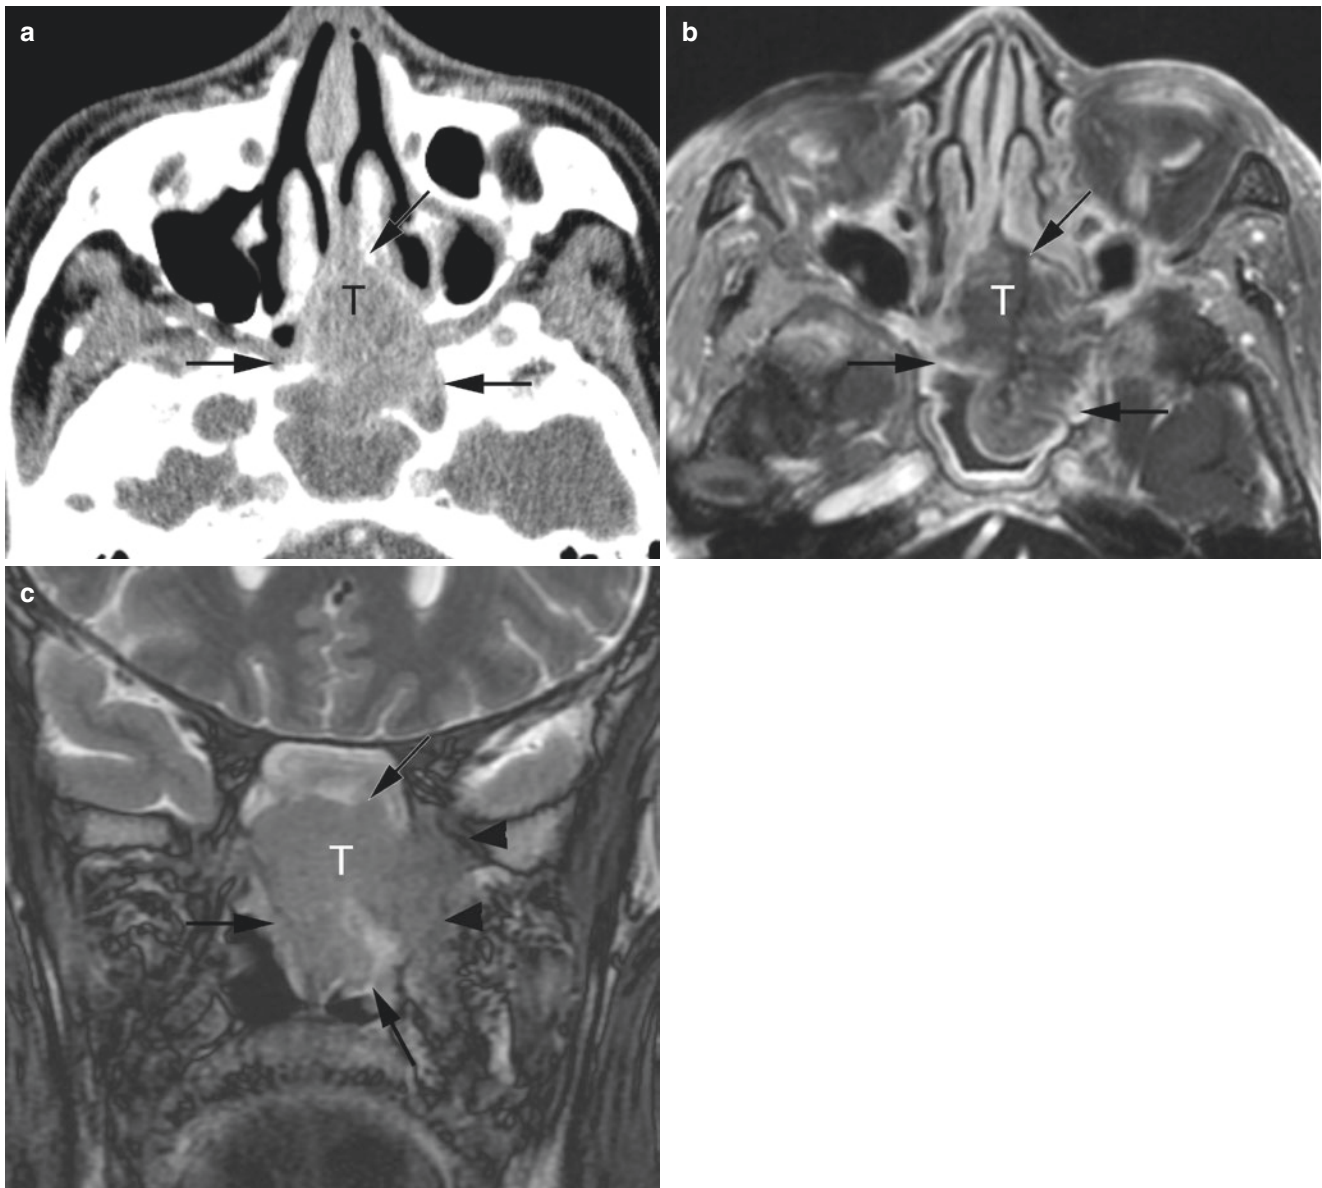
Squamous cell carcinoma of the nasal cavity. (a) Enhanced CT. (b) Axial Gd-enhanced T1-weighted image. (c) Coronal T2-weighted image. CT (a), axial contrast-enhanced T1-weighted (b), and coronal T2-weighted (c) images demonstrate an ill-defined mass lesion (T) in the nasal cavity, extending to the nasopharynx (arrows).
